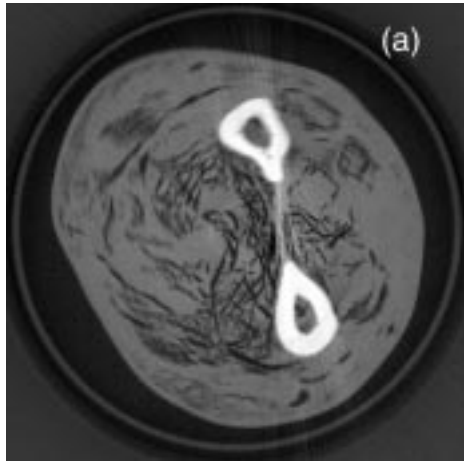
Variable-resolution X-ray CT scan of plasticized human forearm.
